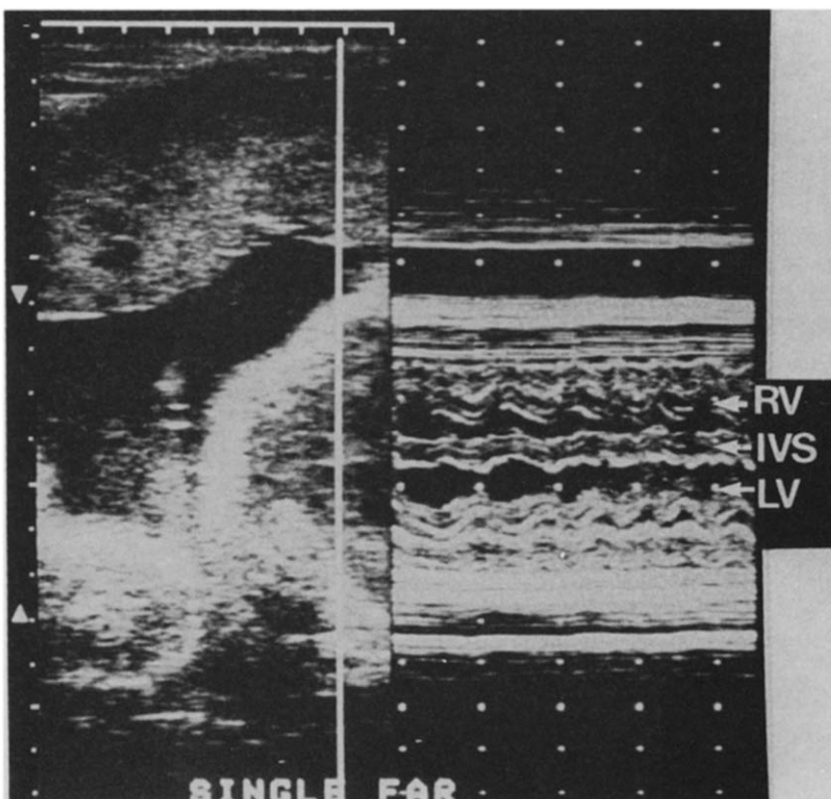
Simultaneously recorded two-dimensional and M-mode echocardiographic study in a 32 week old fetus of a diabetic mother. The thickness of the interventricular septum (IVS) (7 mm) is consistent with hypertrophic cardiomyopathy. LV = left ventricle; RV = right ventricle.
